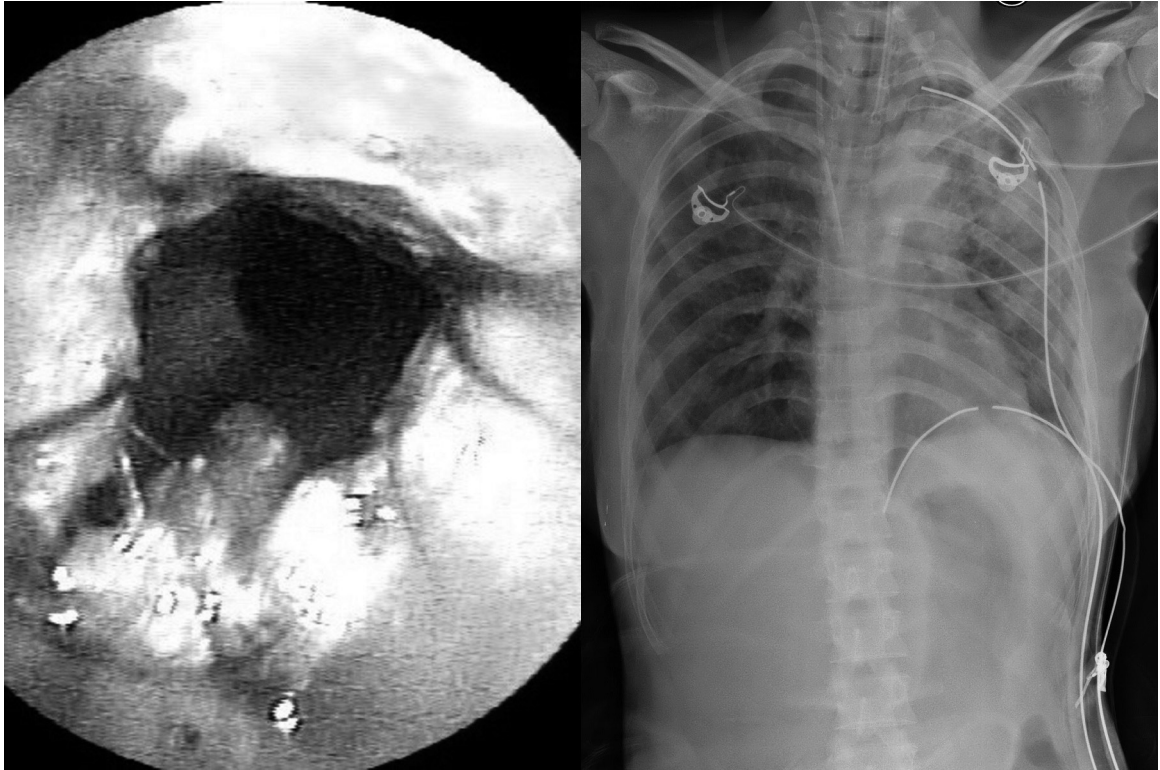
A. Intra-operative bronchoscopy right after sleeve resection and reconstruction of the left main bronchus on PTD 40. B. Initial postoperative chest plain film.
